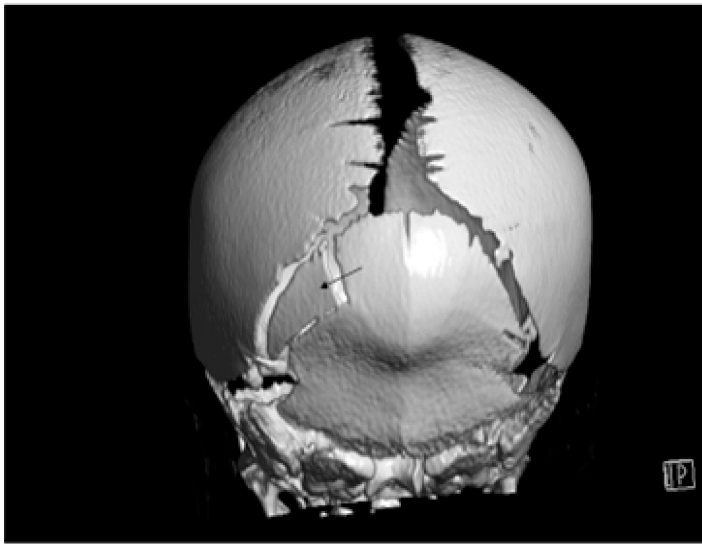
Head CT scan demonstrates very clearly a depressed fracture of the left side of the newborn's occipital bone (arrow)
